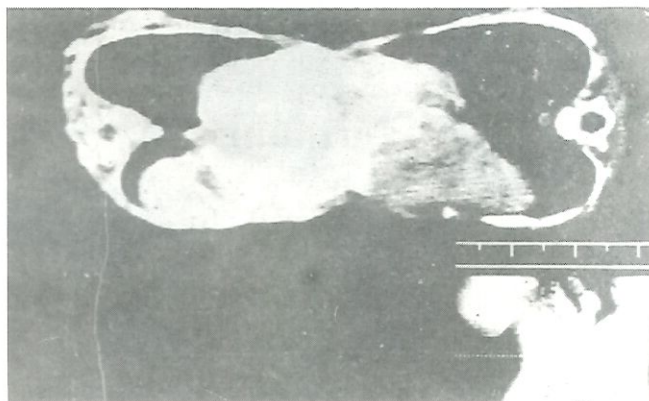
CT scan of abdomen in Twins No. 6.
